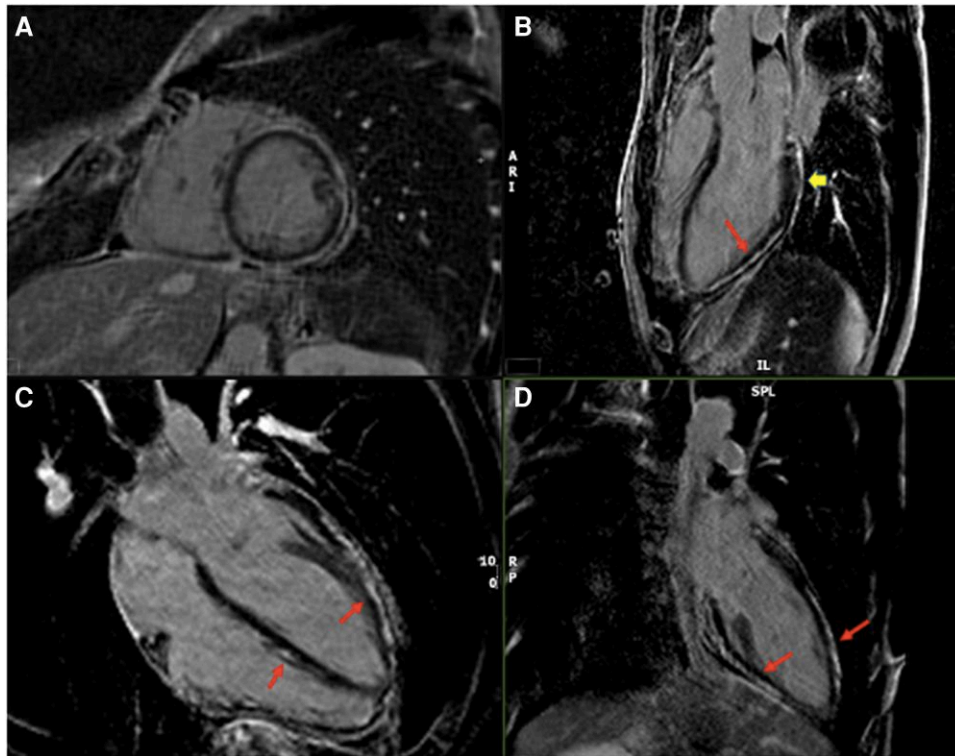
Late gadolinium enhancement pattern on cardiac magnetic resonance imaging of Patient 1. (A) Short axis, (B) three-chamber, (C) four-chamber, and (D) two-chamber views. Long arrows represent myocardial and short arrows indicate epicardial late gadolinium enhancement.
